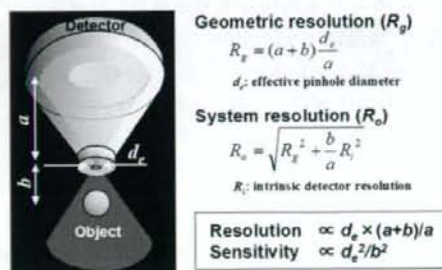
Physics of pinhole SPECT. Spatial resolution and sensitivity can be improved by positioning a collimator closer to an object.
